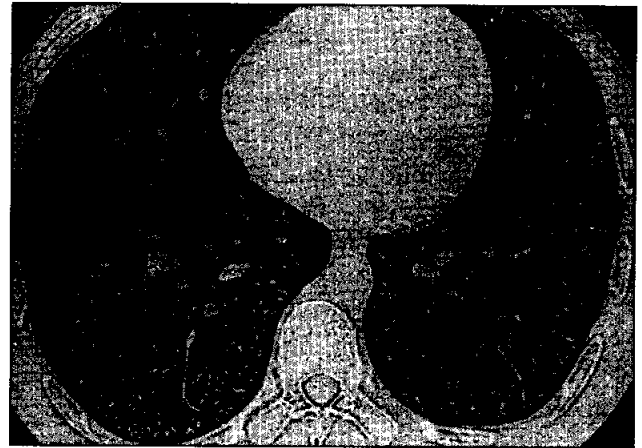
High resolution computed tomography of patient 3 with 1 mm collimation, showing miliary nodules with a mainly interstitial distribution
